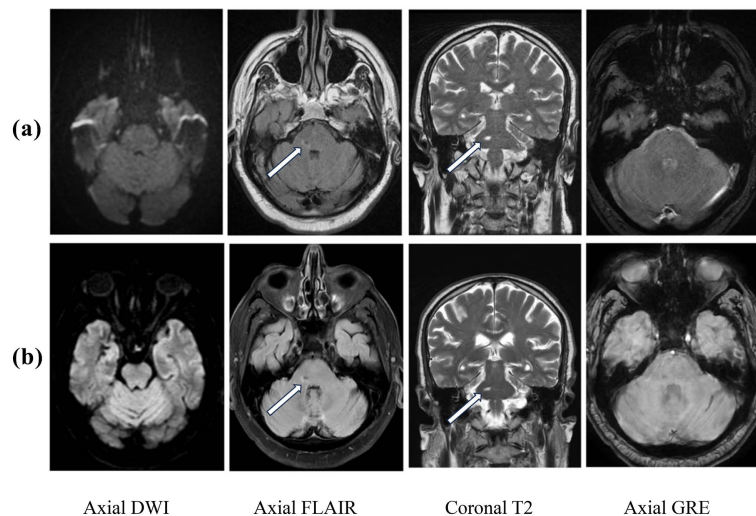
Follow up MRI of the brain at 1-year (a) and 13-years later showing stable post-ischemic stroke changes and encephalomalacia (Arrows) since depicted by axial FLAIR and coronal T2WI and negative DWI. Axial GRE is negative for bleed in both MRI.
